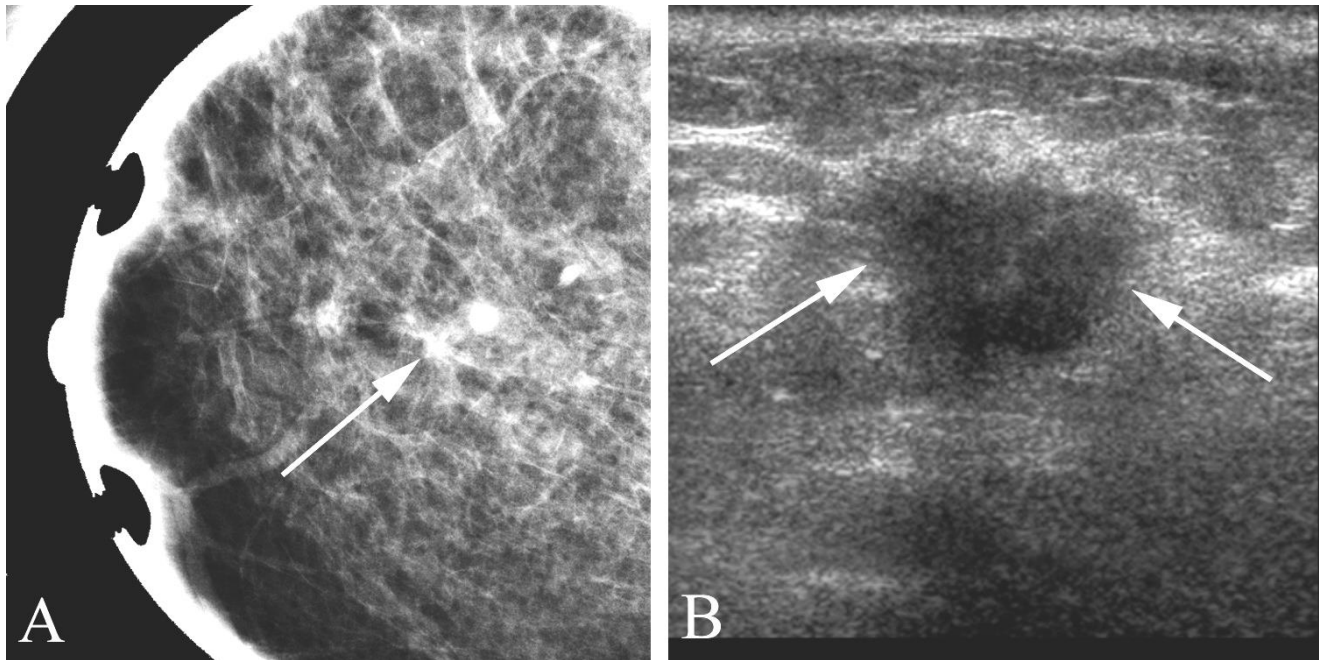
Infiltrating ductal carcinoma in a 75 year old woman with a palpable lesion found at clinical breast examination. A. Craniocaudal mammogram spot compression views (following initial full field exam) shows a subtle lesion of the right breast by the radio-opaque marker. B. Breast ultrasound demonstrates a hypodense, shadow-casting, irregular lesion (arrows) worrisome for malignancy. Biopsy revealed infiltrating ductal carcinoma.
